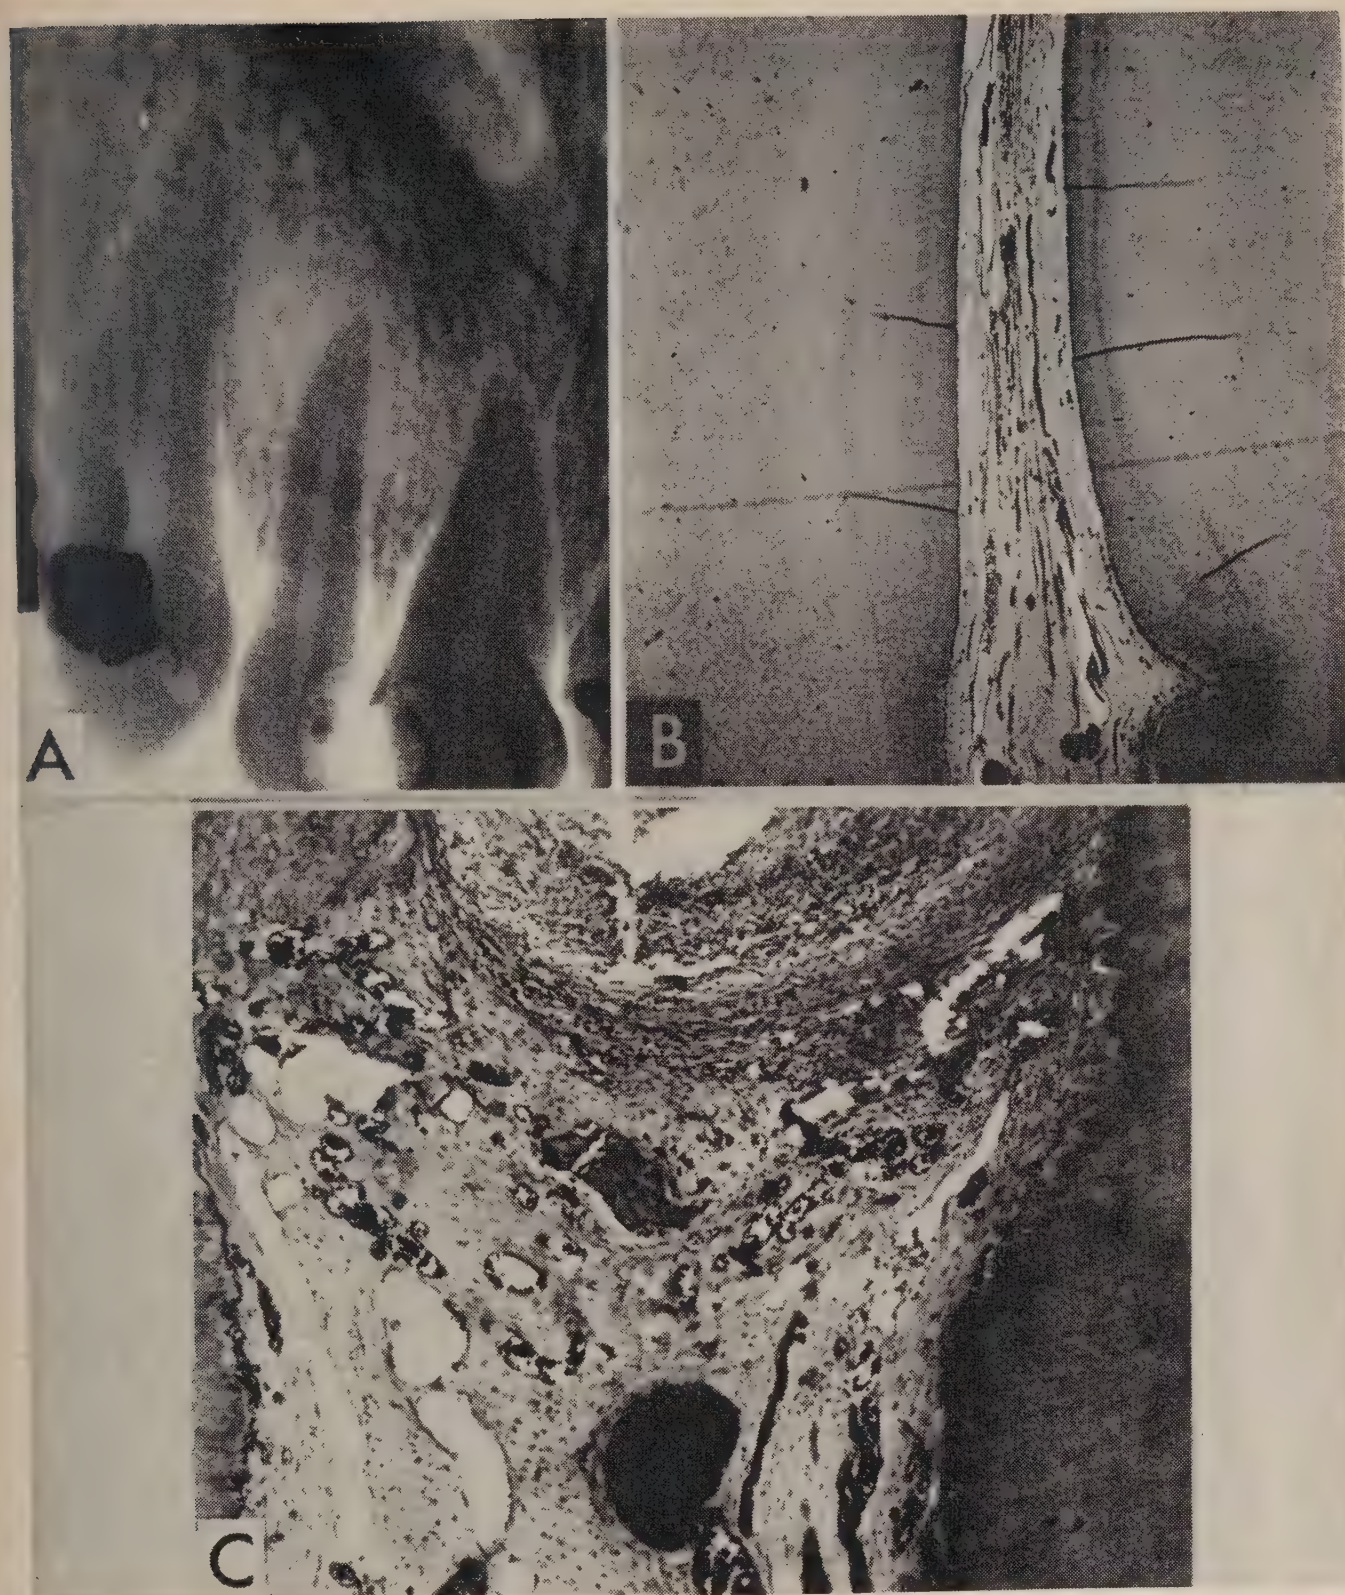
Pâte Ledermix (6 jours); ciment Ledermix (88 jours); 3+ pulpe spontanément douloureuse; femme de 40 ans; 94 jours après coiffage. A, La radiographie prise avant l'extraction ne révèle rien de particulier. B, La vue d'ensemble met en évidence une forte hypérémie dans l'ensemble de la pulpe. H.E. x 12. C, Les détails de la région du coiffage révèlent l'arrêt de la dentinogenèse et la présence d'une inflammation chronique de la pulpe. H.E. x 180.
